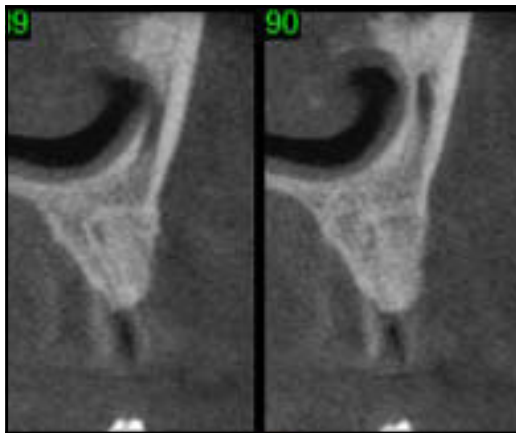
CT scan at 6 months demonstrating radiopacity resembling reconstruction of the ridge at the biopsy site.
